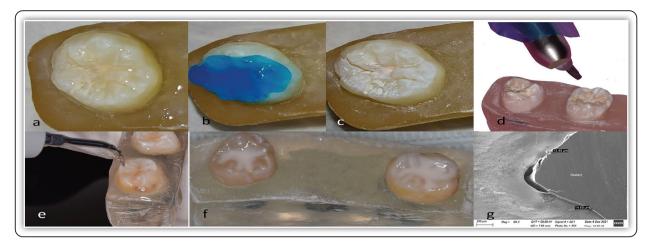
a-c, Acid conditioning of pit and fissures show Chalky white prepared occlusal surface, d, teeth preparation with Air abrasion, e, teeth preparation with ultrasonic, f, Sealant application, and g, depth of resin penetration
